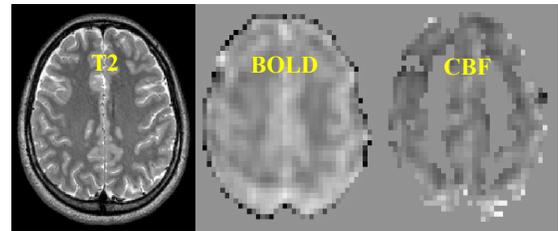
a) top: T2-weighted, and relative BOLD and CBF maps for a representative healthy subject b) bottom: graphs for signal changes in BOLD (red) and in CBF (blue)
